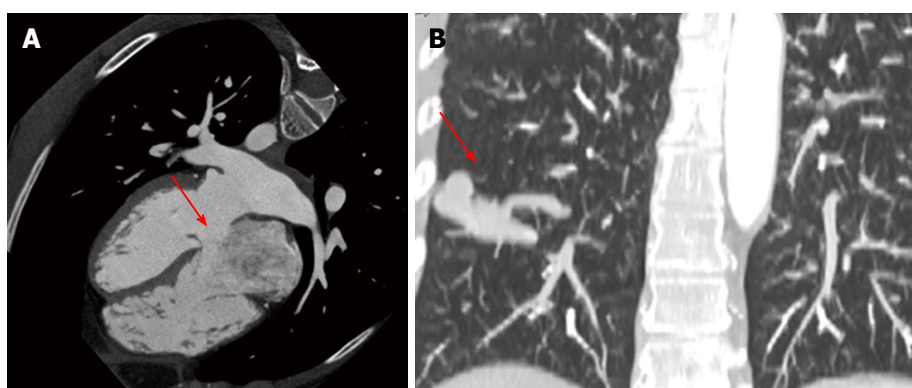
Examples of collateral findings detected with the preprocedural cardiac computed tomography. A: Ostium primum atrial septal defect (red arrow); B: Abnormal dilated vessels (red arrow) diagnostic for pulmonary arteriovenous malformation located in the lower lobe of the right lung.
